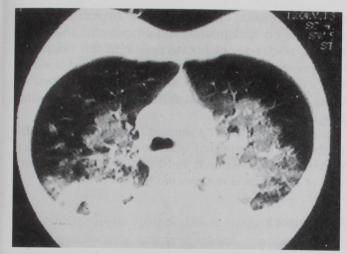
Computed tomography of the chest performed 3 h after onset of the symptoms showing patchy bilateral ground glasses, macronodular opacities, and alveolar consolidation without pleural effusion.
